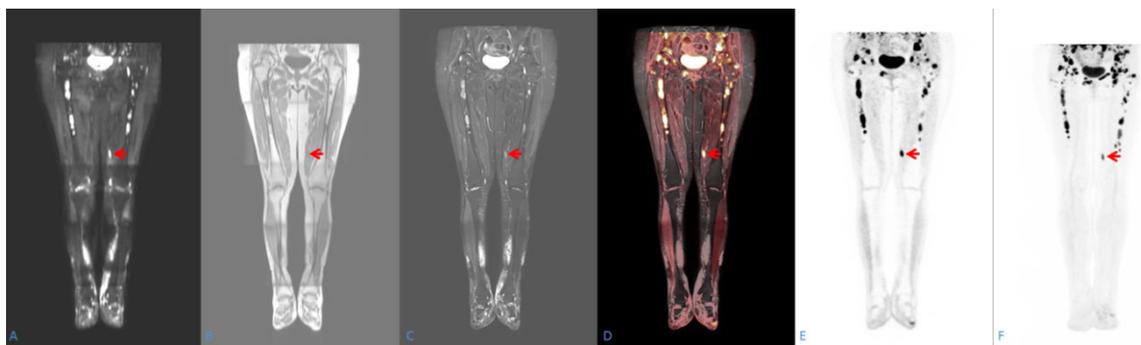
MM manifestations on coronal DWI (A), T1W (B), TIRM (C), Fused PET/TIRM MR (D), PET images (E) and on 3D MIP anterior aspect PET dataset (F) of the lower extremities. At the medial side of left distal femoral region, among the muscles circumscribed soft tissue lesion (red arrow) with focal low T1 signal intensity (B), high DWI (A) and TIRM (C) signal intensity and intensive FDG accumulation respectively (D-E-F).
